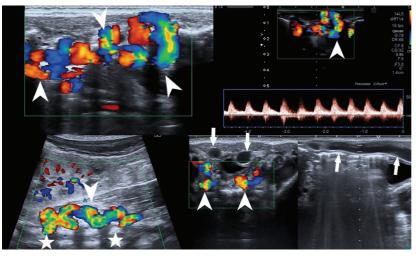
Ultrasound with Doppler of the abdominal vessels showed tortuous paraspinal vessels with a right-side predominance (arrowheads) and two thick collaterals originating from iliac arteries (arrows) and running cranially in the anterior abdominal wall (star – along the spine).
